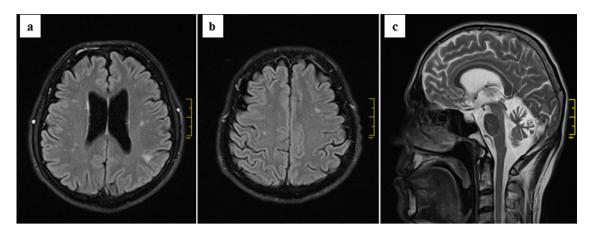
Proband's brain MRI: (a, b) diffused hyperintensive lesions in both hemispheres on FLAIR images; (c) cerebellum atrophy on T2-weighted image.
